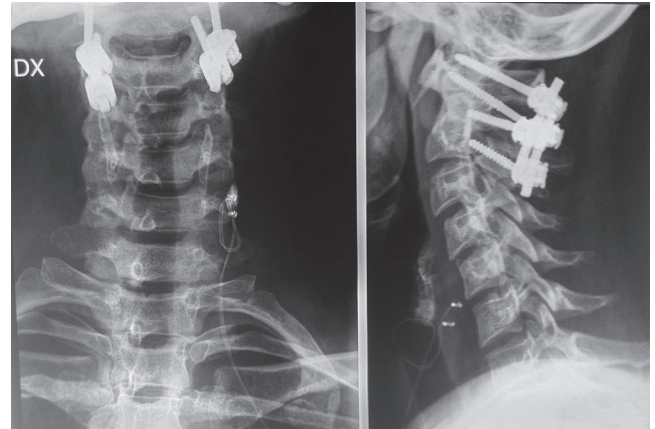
X-Ray (XR) scan 1 year after surgery.
